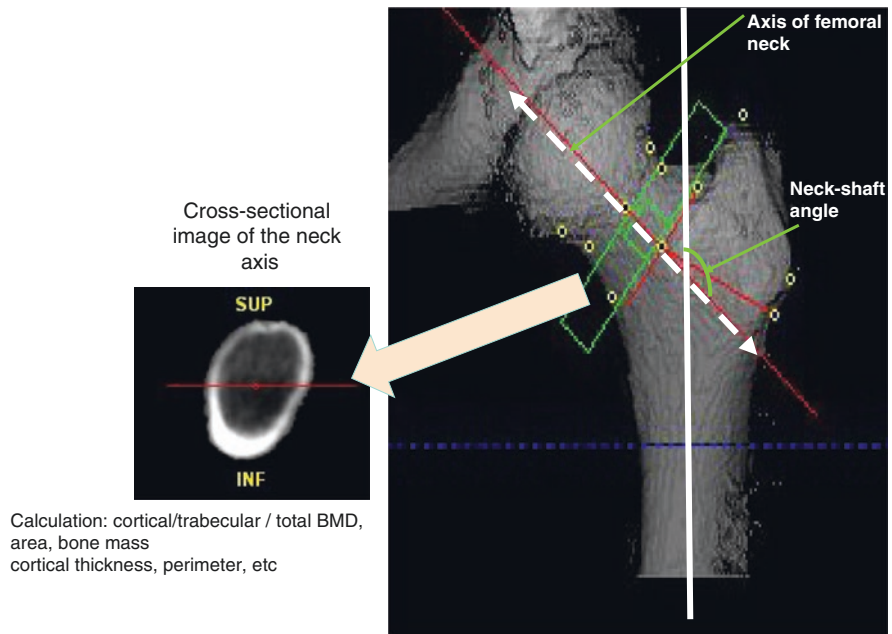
Hip BMD and structure analysis using three dimensional (3D)-QCT. Using reconstructed 3D CT data, the axis of the femoral neck (FN) can be exactly obtained three-dimensionally. On the basis of FN axis, an FN cross-sectional image is obtained to calculate several parameters, such as BMD, bone mass, bone area, curvature, and cortical thickness. Bone biomechanical indices such as cross-sectional moment of inertia (CSMI), section modulus (SM), and buckling ratio (BR) also induced from these geometrical parameters
